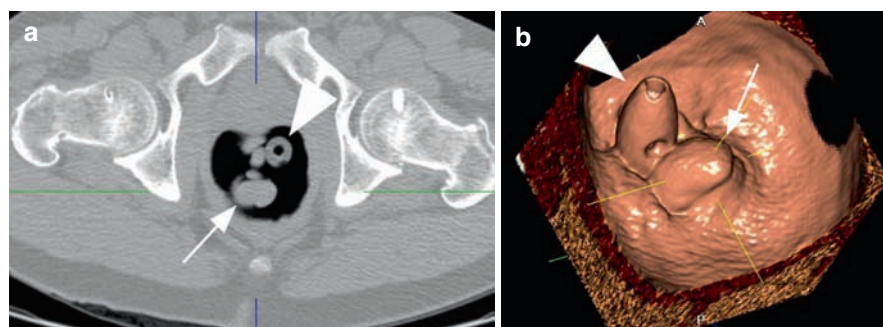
Sixty-eight-year-old male with large internal hemorrhoids found by endoscopy. (a) axial CT image, (b) 3D endoluminal image at CT colonography. Note the smoothly
